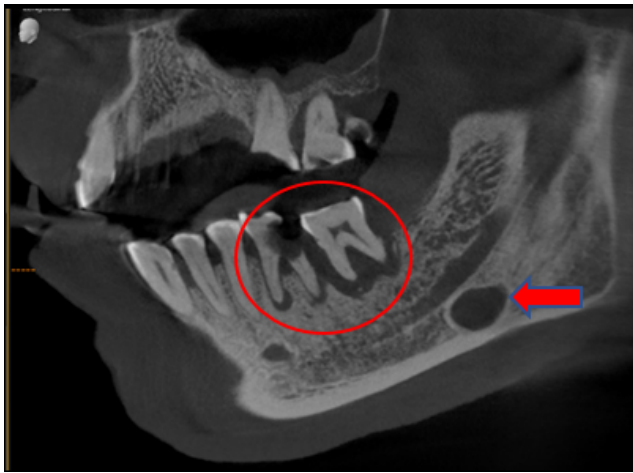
Longitudinal section of CBCT showing periapical pathology with 36, 37 and also showing an unilocular radiolucency involving body of mandible.
